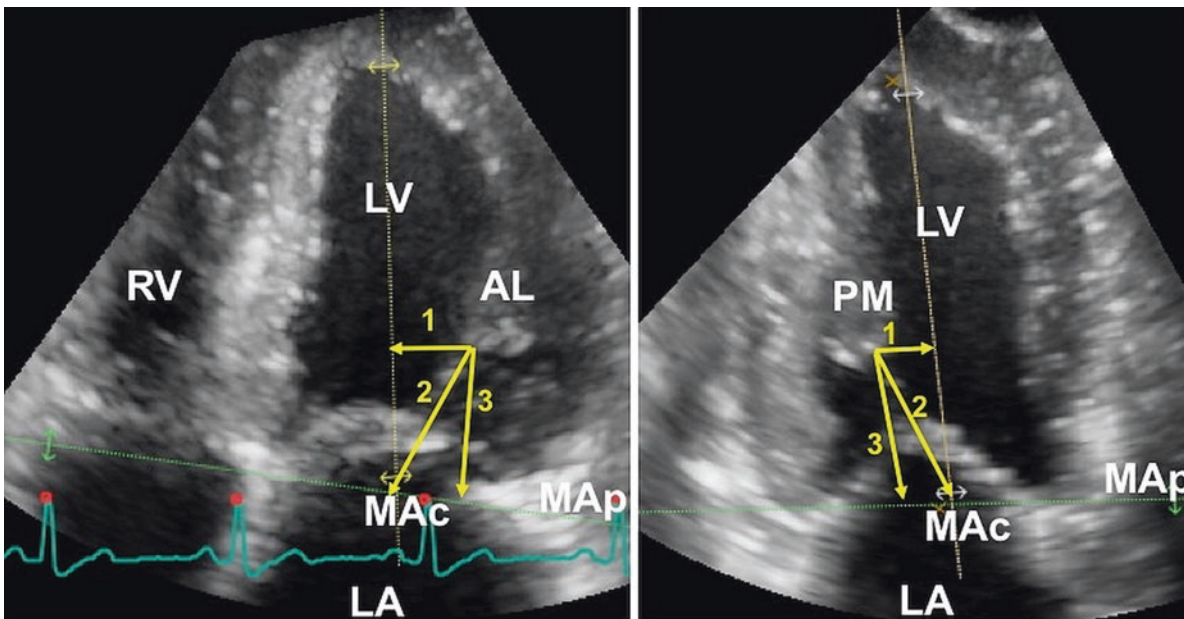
Full volume 3DE data set of the left ventricle obtained with transthoracic echocardiography and cropped in a longitudinal axis to visualize both papillary muscles (Video 7.6). *AL* anterior-lateral papillary muscle, *PM* posterior-medial papillary muscle (with double head); *MV* mitral valve
